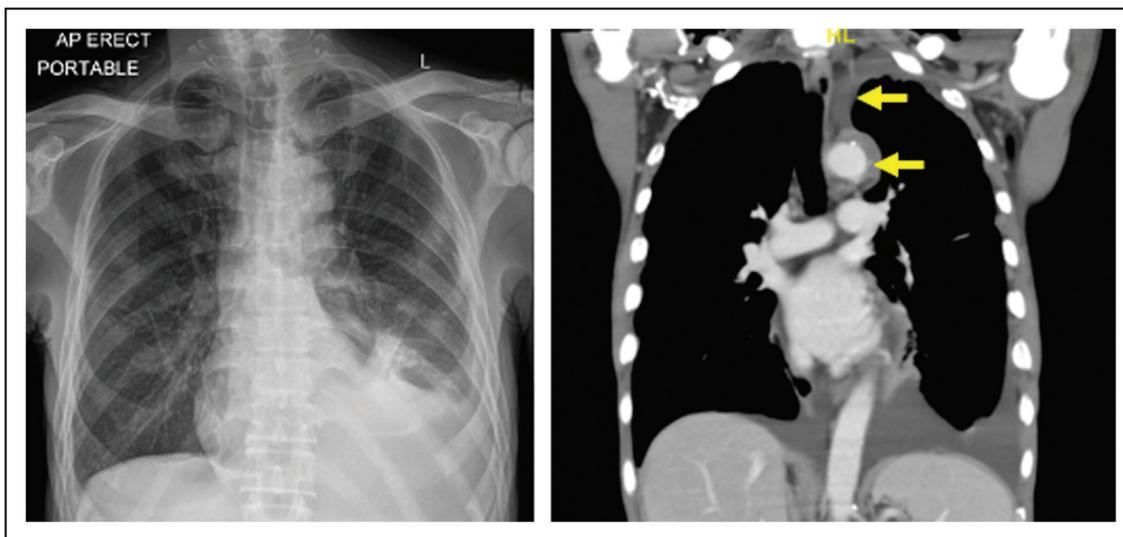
Unilateral pleural effusion with mediastinal pleural thickening. Example of a patient with unilateral exudative pleural effusion and mediastinal pleural thickening on computed tomography scan of the chest. This was not amenable to image-guided percutaneous pleural biopsy. MT was pivotal in clinching the diagnosis.
